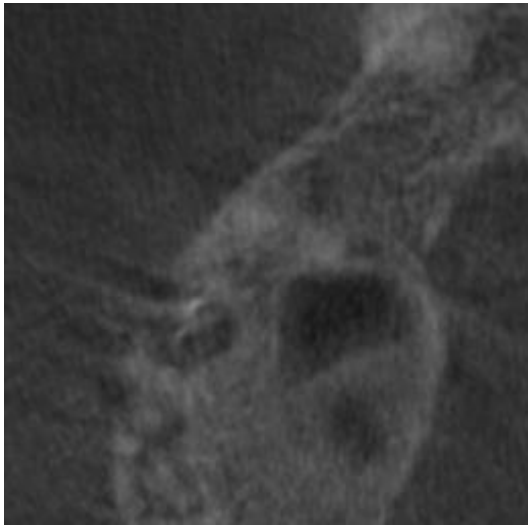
CBCT Axial View of #3
